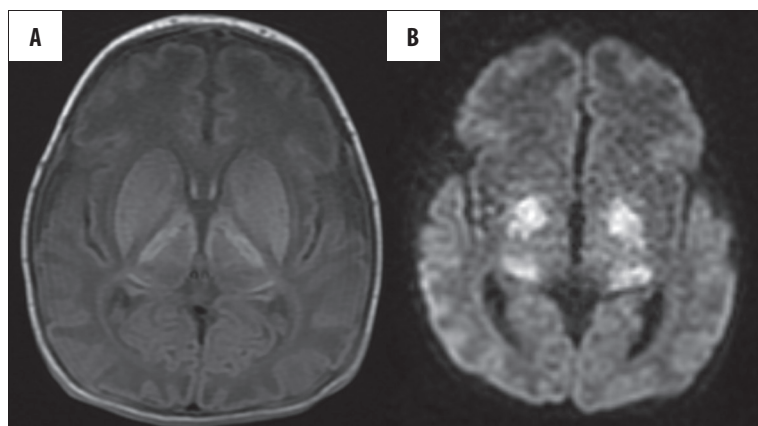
Injury of basal ganglia and thalamus in a term newborn – features of acute asphyxia. The lesions are hyperintense in all types of sequences (T1, T2, FLAIR) they show diffusion restriction. (A) SE/T1,ax; (B) DWI.
